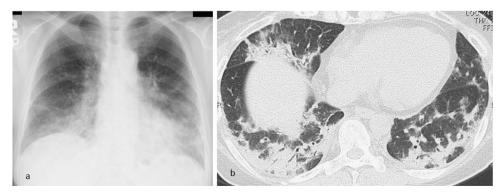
Chest radiologic imaging findings in a 60-year-old woman with recurrent gastric cancer. (a) Chest radiograph shows linear and ground-glass shadows in the bilateral lungs, predominantly in the lower lung fields. (b) Computed tomography on admission shows bilateral airspace consolidation, predominantly in the peribronchial area, with irregular margins and areas of ground-glass opacities.
